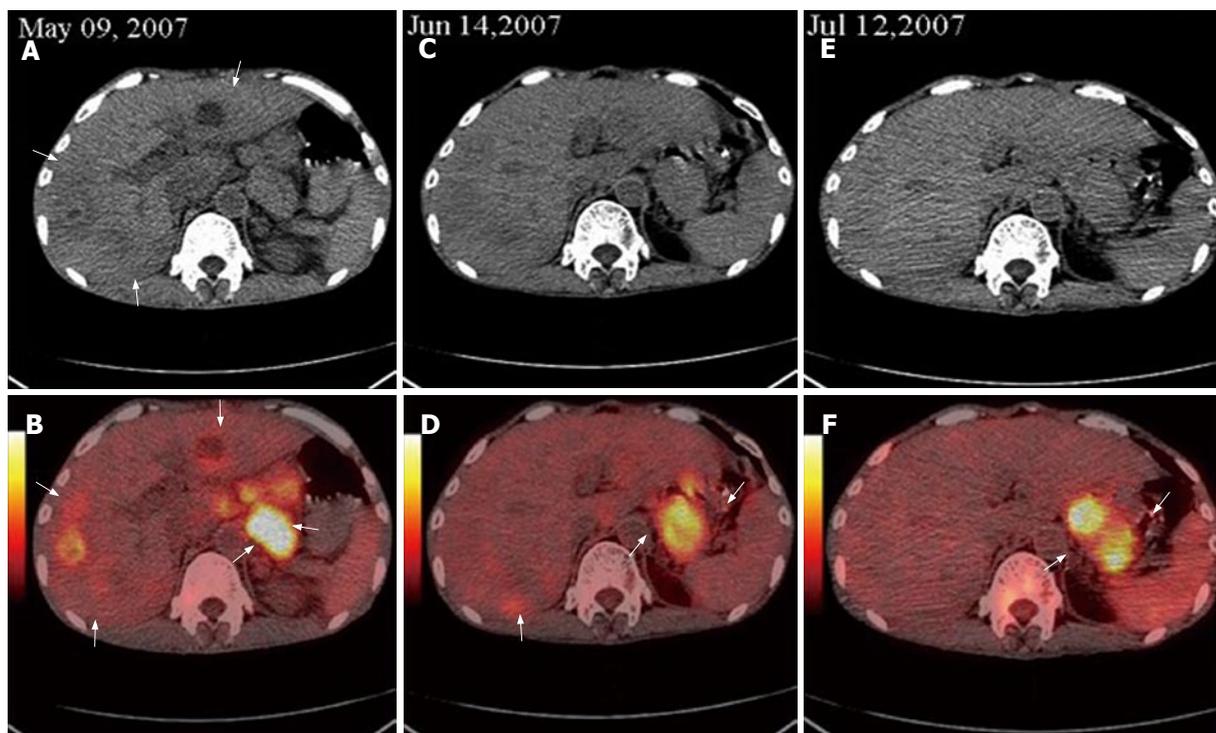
Base line FDG PET/CT detecting multi high metastases in both lobes of liver and highly metastatic lymphoid nodes in abdomen (white arrows, A and B), second FDG PET/CT demonstrating multi high metastases in the liver and the decreased number, size and metabolism level of metastatic lymphoid nodes (white arrows, C and D), third FDG PET/CT displaying disappeared liver metastasis and metastatic lymphoid nodes (E and F).
